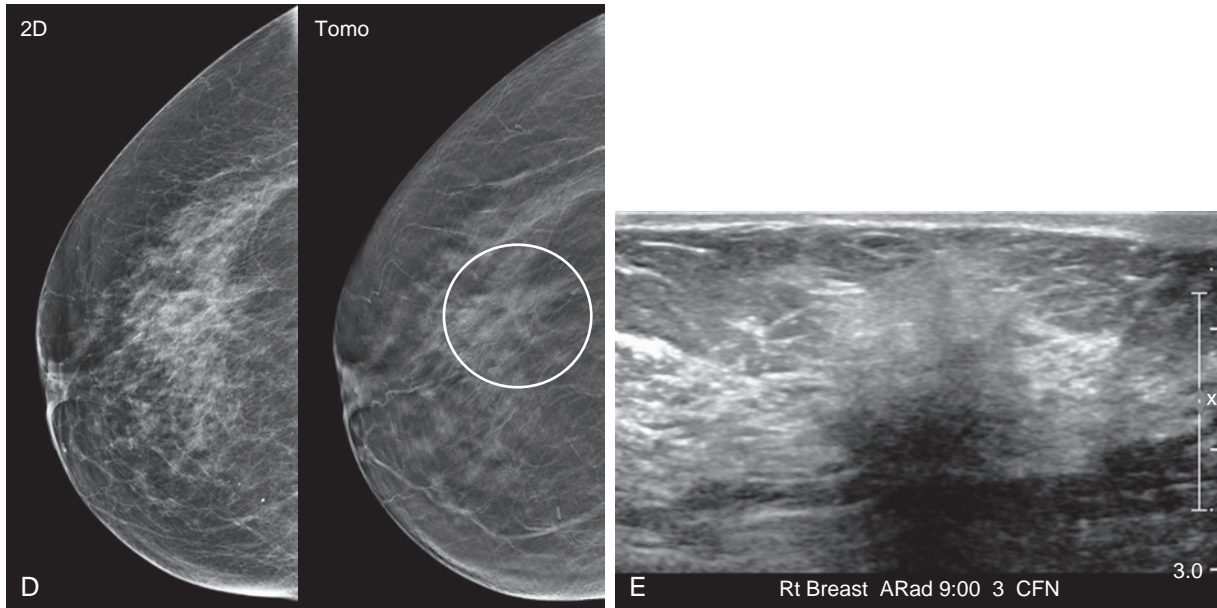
cont'd (D) Mammography shows a subtle focal asymmetry in the right breast (*circle*), centrally, best appreciated on tomosynthesis. (E) Ultrasound shows an irregular, hypoechoic lesion with indistinct margins. Ultrasound biopsy revealed invasive lobular carcinoma, ER+/PR–/Her equivocal.
